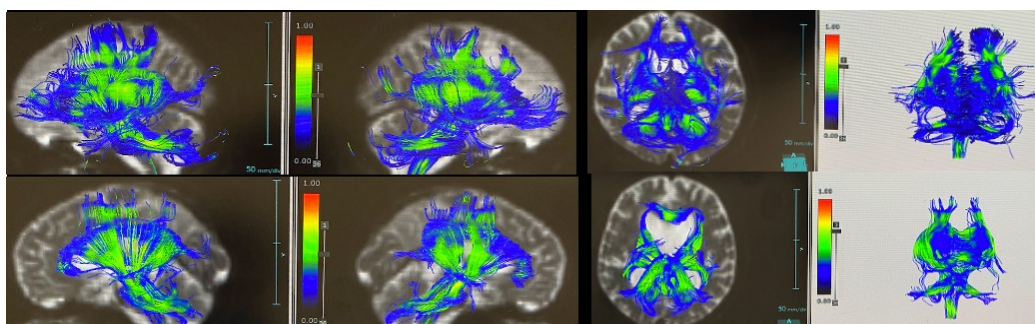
MRI Diffusion Tensor Tractography in patients with Alzheimer's disease
